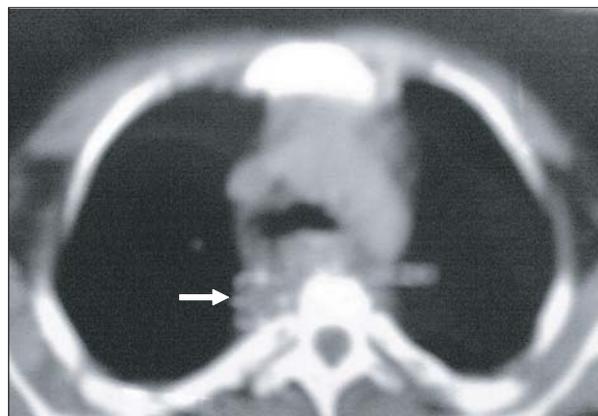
CT scan of chest showing paravertebral abscess (arrow).
